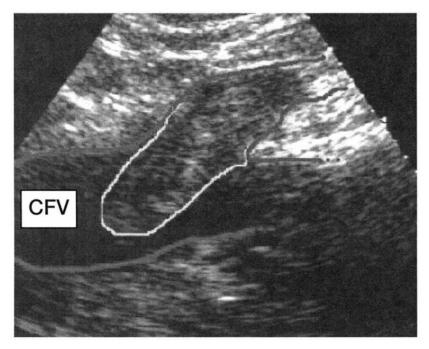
Ultrasound image of a clot (outlined in white) originating in the treated great saphenous vein extending into the common femoral vein (CFV) lumen, partially occluding the deep vein. (Photo courtesy of Olivier Pichot, M.D., reproduced with permission).
